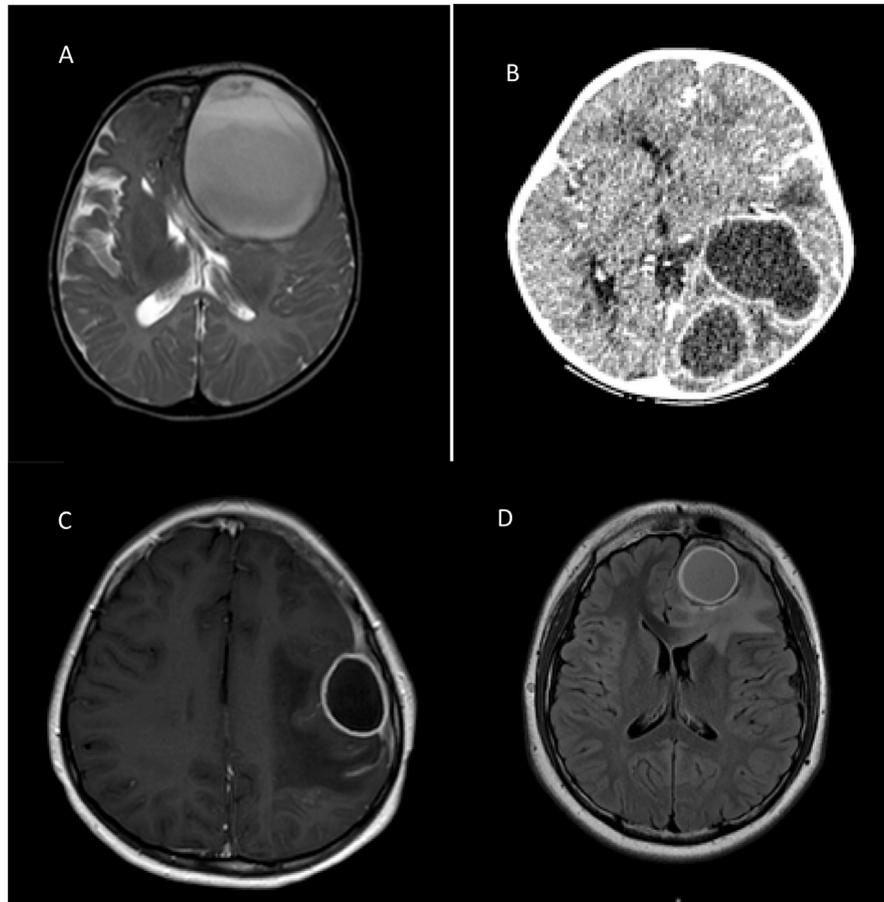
Cranial MRI/CT findings of 4 patients.
